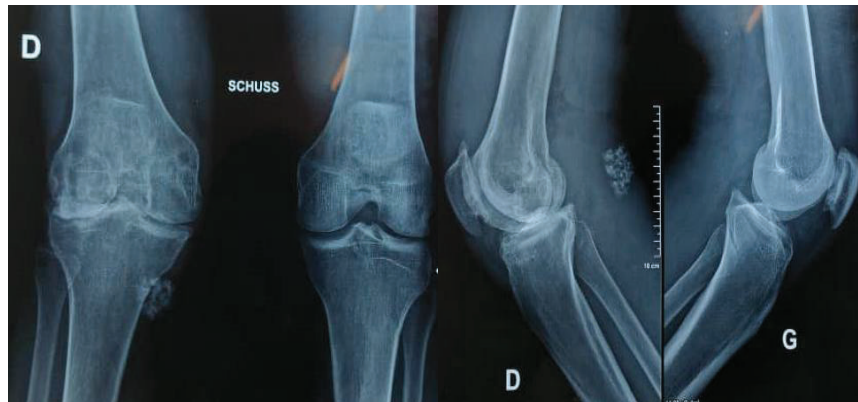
X-rays of the Schuss e profile knees, bilateral tri-compartmental gonarthrosis with hyarthrosis much more marked on the right, heterogeneous calcification and oval projection of the posterior soft tissues of the right knee
